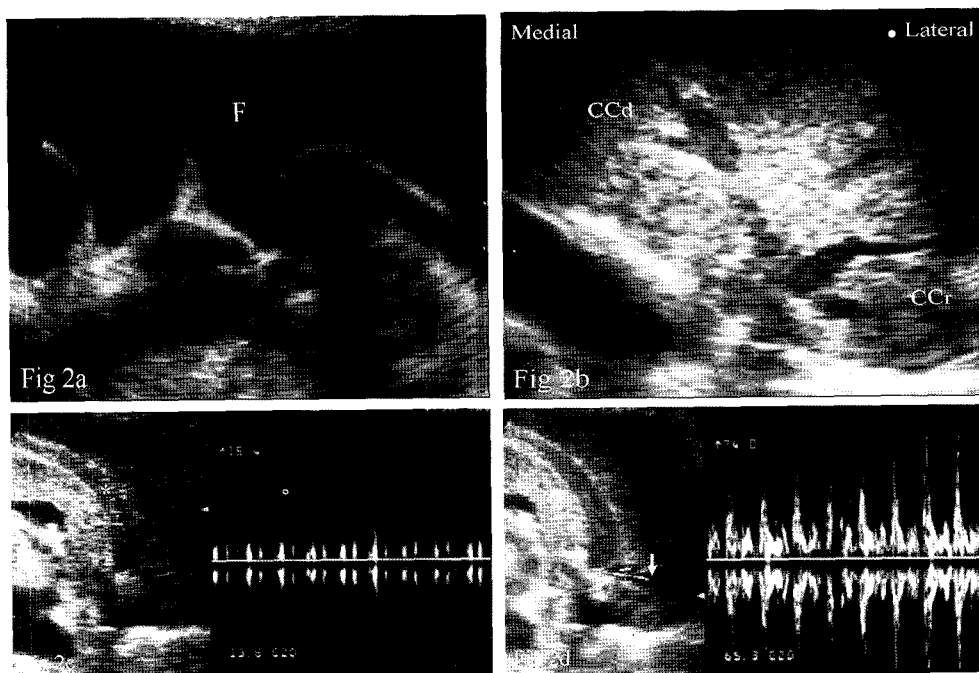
Non-cardiac ultrasonography. Large amount of pleural effusion (F) in left thoracic cavity and homogenous, liver-like echogenicity of the left cranial lobe were observed (a). Consolidated lung lobe containing pulmonary vessel and the apex of consolidated caudal part of left cranial lobe (CCd) was projected toward cranio-medial direction and cranial part (CCr) toward caudo-lateral direction (b). The tortuous pulmonary vessel (*) of caudal part had hyperechoic lumen and no signal in spectral Doppler examination (c), but anechoic pulmonary artery (arrow) of cranial portion showed pulsed wave (d).
